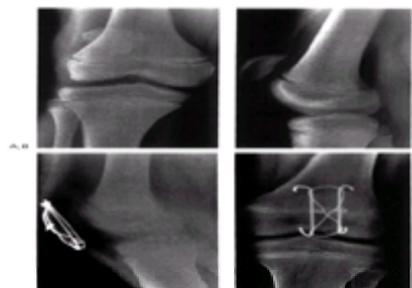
Patella injury. A: An anteroposterior radiograph of the knee suggests proximal displacement of the patella. B: The lateral view demonstrates patella alta, and a faint calcification is seen 1 cm distal to the inferior pole of the patella. These findings are consistent with patellar sleeve fracture. C: Lateral view after open reduction and fixation with AO tension band technique. The patella has returned to its normal position. D: The anteroposterior projection shows the configuration of the internal fixation devices.
